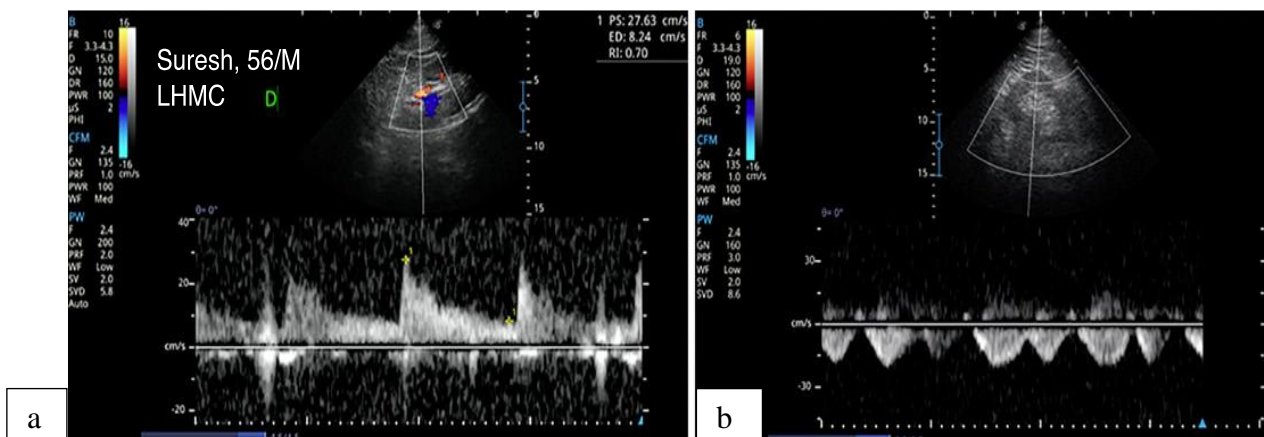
Depicts doppler volume position in the interlobar vessels, intrarenal artery flow. b Pulsatile venous pattern.
